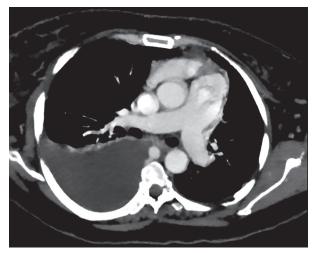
Axial postcontrast CT section showing main pulmonary trunk with right and left pulmonary arteries with mass extending into the main pulmonary trunk
